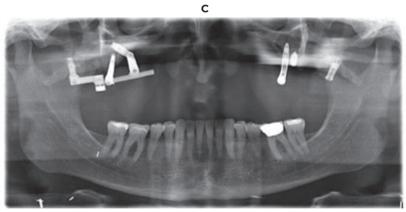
A patient presented with a Brown class IId defect [21] after avascular necrosis after Le Fort I osteotomy. (a) Bar construction was made on the dental implants to support the obturator, where the space was too large between two implants, magnet abutments were used as alternative retention method. (b) Retentive parts in the obturator prosthesis.(c) Panoramic radiography showed the position of dental implants in remaining bony parts of the midface or skull base.
